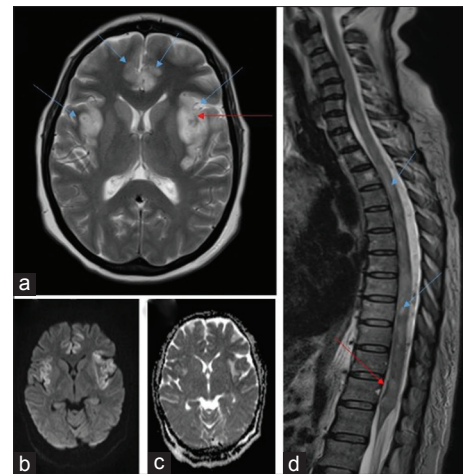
(a) T2-weighted axial image of the brain shows swelling and hyperintensity of the insular cortex and cingulate gyri (blue arrows) with a focus of hemorrhage within (red arrow). (b and c) Diffusion-weighted images and apparent diffusion coefficient maps show evidence of diffusion restriction in the insular cortex and cingulate gyri, (d) T2-weighted sagittal image of the spine shows diffuse swelling with patchy areas of hyperintensity (blue arrows) and small foci of hypointensity (red arrow) suggestive of hemorrhage in the cord
